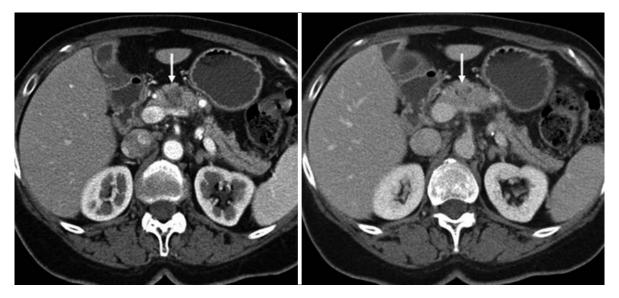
Dual phase MDCT of pancreatic cancer. Axial CT obtained during the pancreatic phase of enhancement (*left*) shows 2 cm hypo-vascular pancreatic adenocarcinoma (*arrow*). During the portal venous phase (*right*) the tumor is isoattenuating (*arrow*)
